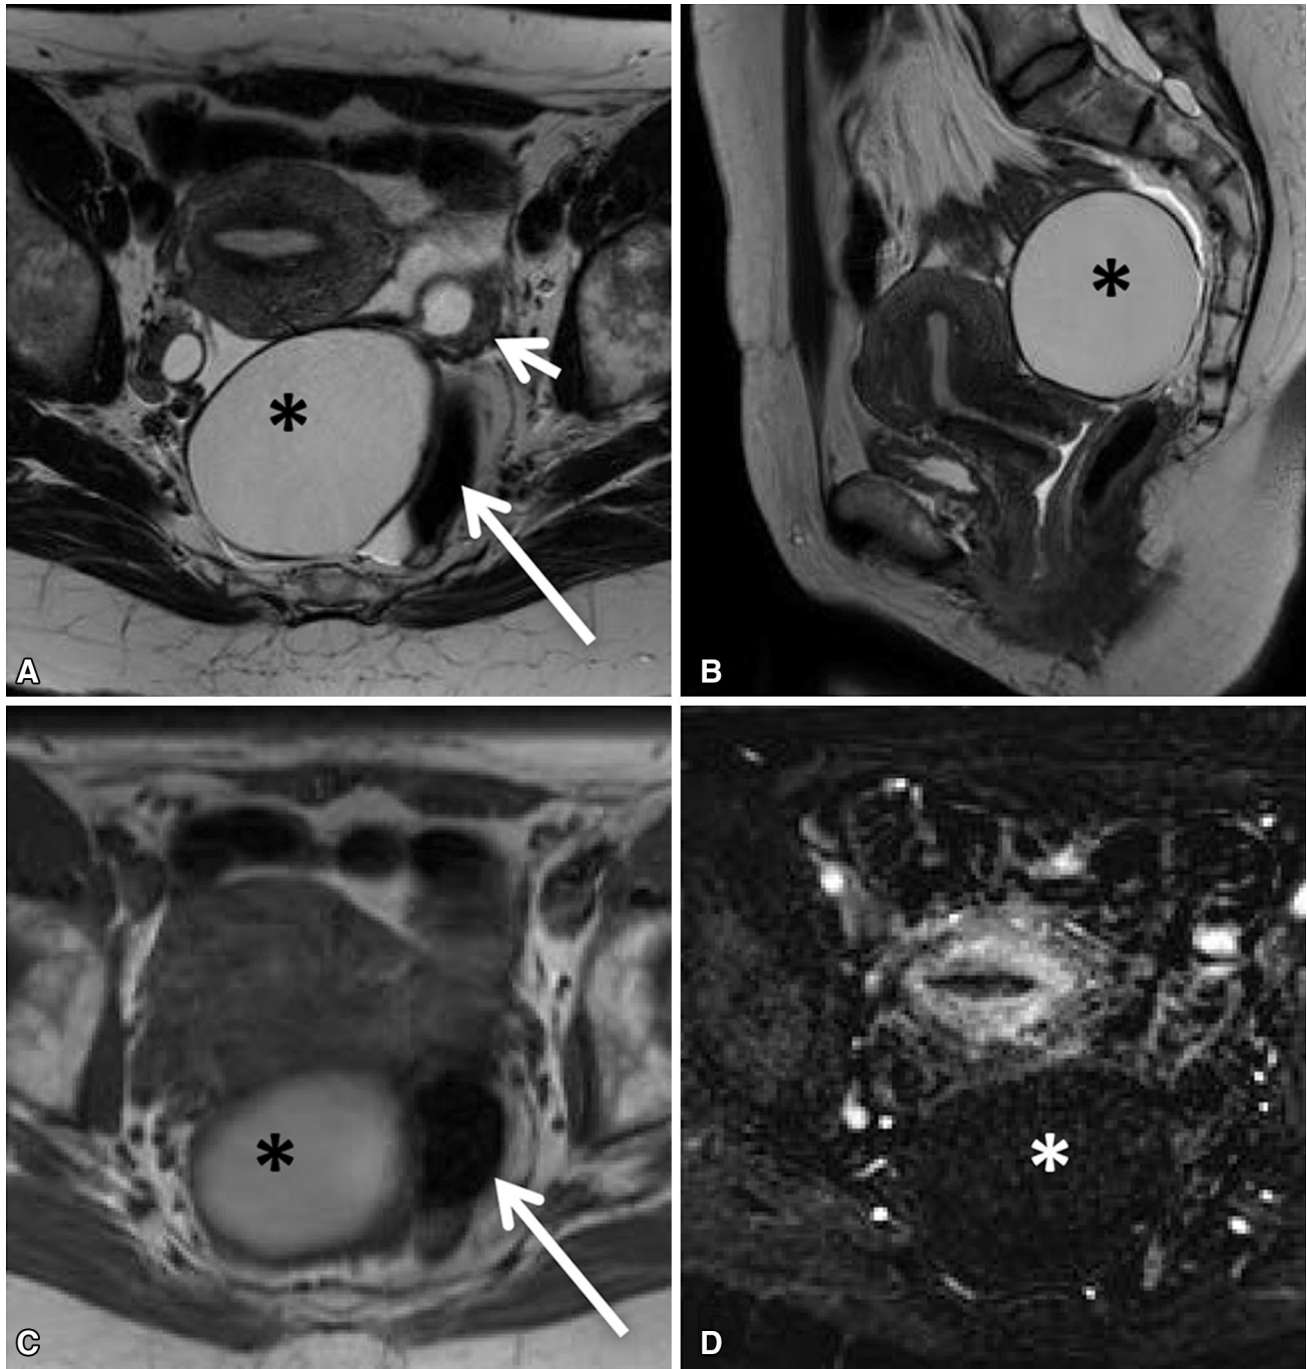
Surgically proven ovarian papillary serous cystadenofibroma. A Axial and B sagittal T2-weighted images show a hyperintense cystic lesion (asterisk) arising from the left ovary (short arrow). The lesion displaces the rectum laterally (long
